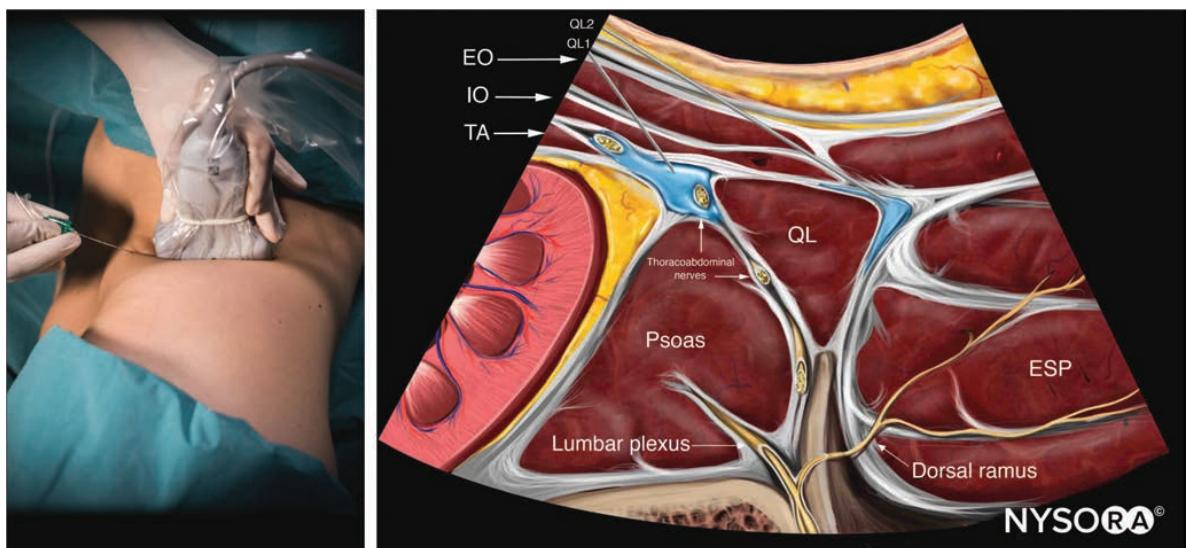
Reverse ultrasound anatomy of a QL1 or a QL2 block with needle insertion in-plane. EO, external oblique muscle; IO, internal oblique muscle; TA, transversus abdominis muscle; QL, quadratus lumborum; ESP, erector spinae muscles.
